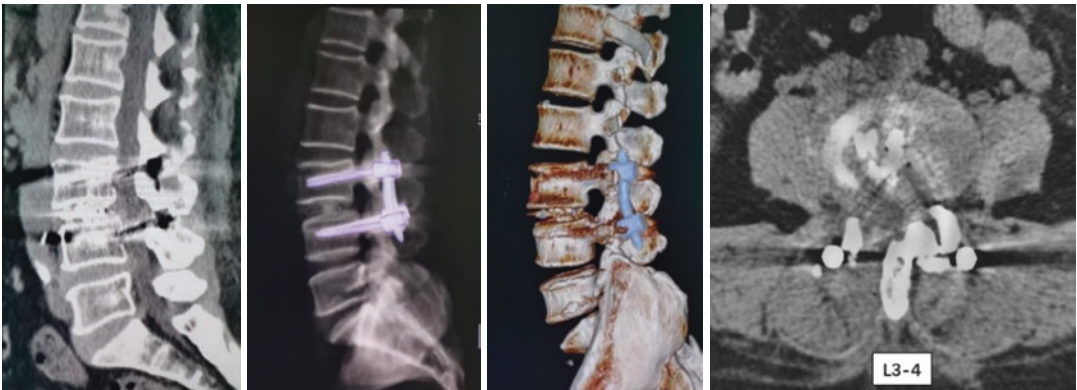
Postoperative CT scan
